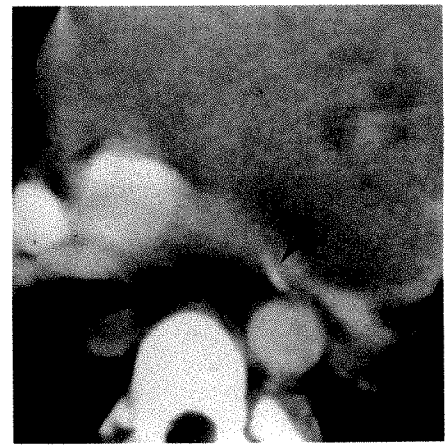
CT scan shows a small streak of calcification (arrow) in expected location of ligamentum arteriosum. This patient had newly diagnosed lymphoma; we originally had thought calcification was part of mediastinal mass.
